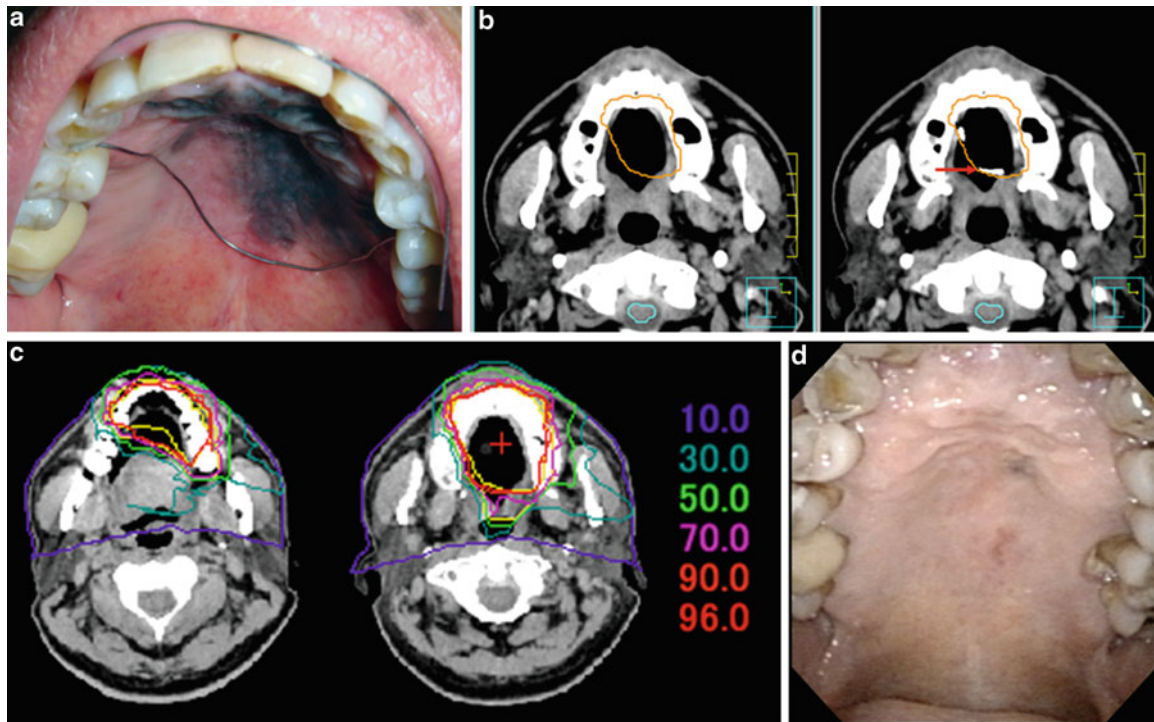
Left palate MMM in a 61-year-old male patient. (a) Intraoral view of the lesion and placement of a metal wire (arrow) to clearly outline the tumor. (b) Image fusion of the planning CT (left) and CT
